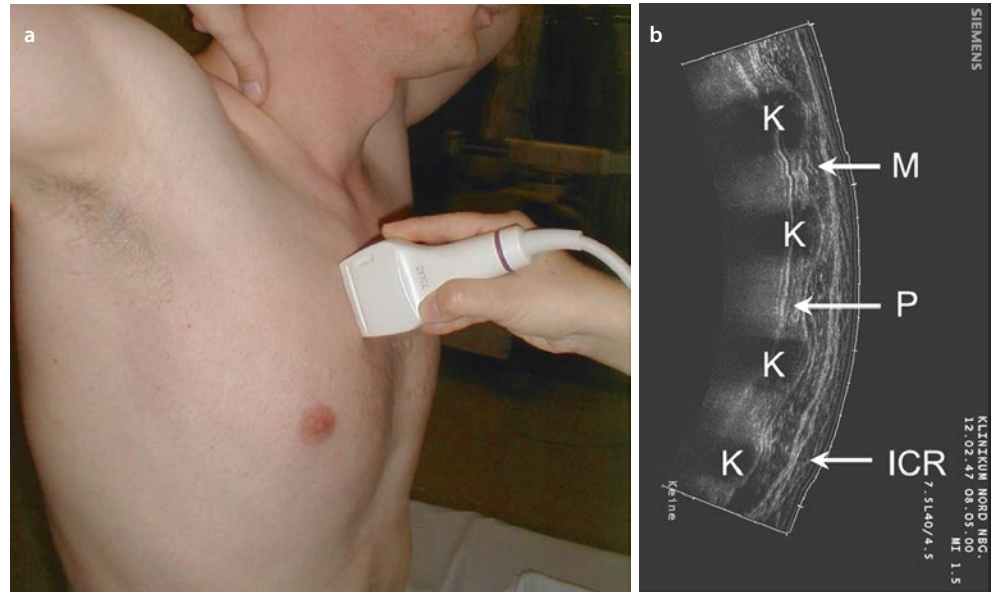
Investigation of the seated patient. a Linear probe placed parallel to the ribs in the third intercostal space. b Corresponding transverse panoramic ultrasound image (SieScape). *M* muscle, *P* pleural line
